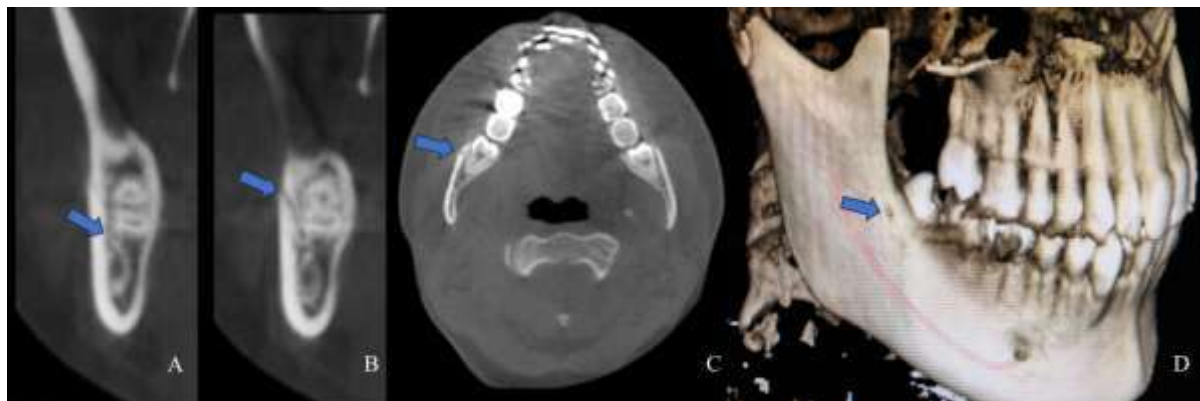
(A) An accessory canal arising from the superior surface of the main inferior alveolar nerve canal in close proximity with impacted mandibular right third molar in a sagittal section of a CBCT scan (indicated by a blue arrow). (B) An accessory canal arising from the superior surface of the main inferior alveolar nerve canal in an upward and forward direction exiting from the buccal cortical plate below the alveolar crest and in close relation to the impacted mandibular right third molar in a sagittal section of a CBCT scan (indicated by a blue arrow). (C) The opening of an accessory canal in the buccal cortical plate in close proximity with impacted mandibular right third molar in an axial section of a CBCT scan (indicated by a blue arrow). (D) A 3D reconstructed image showing opening of an accessory canal in the buccal cortical plate below the alveolar crest in close proximity with impacted mandibular right third molar (indicated by a blue arrow).
